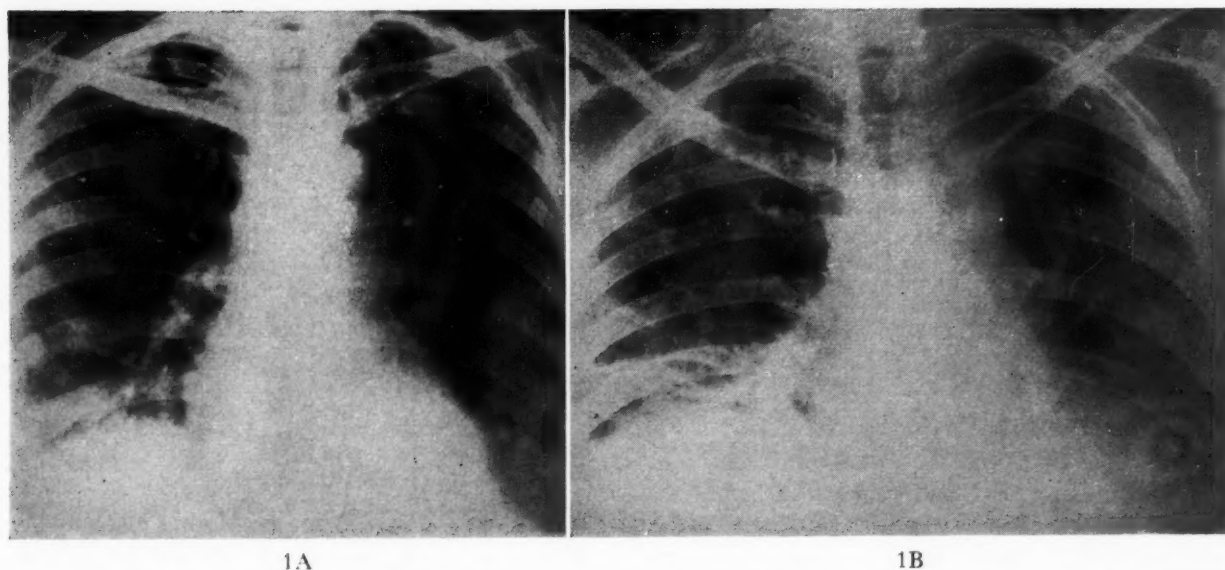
(Case 1.) A, August 25, 1952; faint haziness over both lower lung fields; possibly pleural reaction at bases. B, chest x-ray, February 16, 1953; soft irregular mottlings throughout both lung fields and faint reticular infiltrations; prominent horizontal fissure on right; possibly small collections of fluid at bases; right leaf of diaphragm displaced upward.
